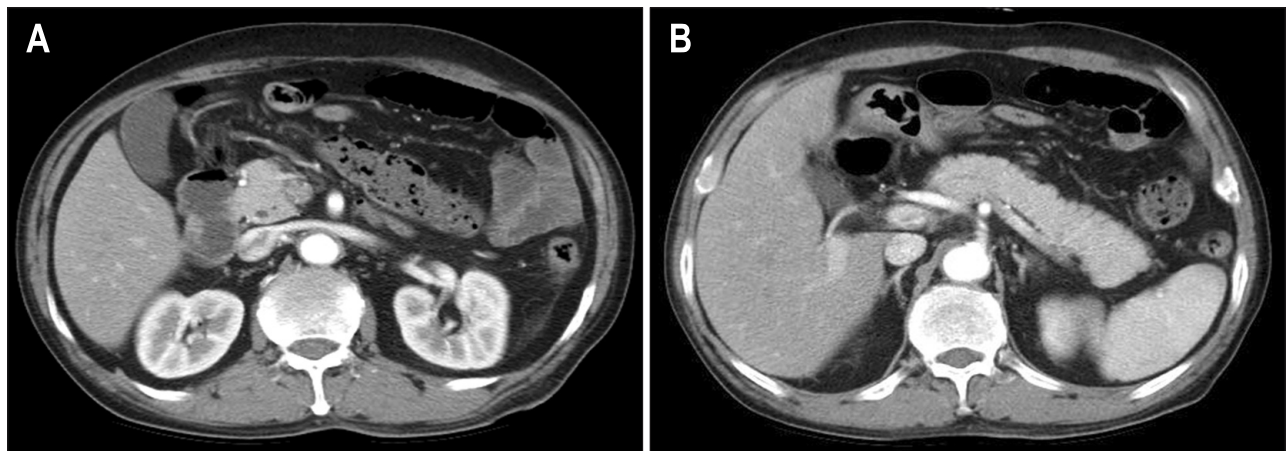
A 71-year-old male presented to the emergency department of our institution with nausea, vomiting, and watery diarrhea over the previous 3 days. Amylase and lipase levels were normal at 130 U/L (reference range, 45 to 160 IU/L) and 51 U/L (reference range, 13 to 60 U/L), respectively. The patient was given 400 mg of intravenous ciprofloxacin twice daily for 2 days. Subsequently, he was given 500 mg of oral ciprofloxacin twice daily for 3 days. On the sixth day of treatment, follow-up laboratory parameters worsened; the serum amylase and lipase activities were elevated to 246 and 566 U/L, respectively. (A, B) Seven days after admission, abdominal computed tomography demonstrated swelling and homogeneous enhancement of the pancreas head and body. The patient was managed conservatively and had an uneventful recovery, and has remained well since discharge. He was diagnosed with probable drug-induced pancreatitis secondary to ciprofloxacin based on the Naranjo algorithm.¹¹
